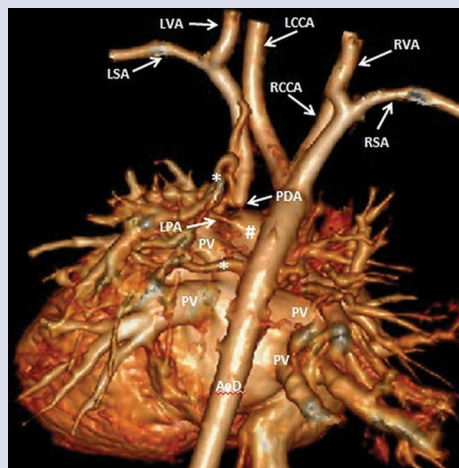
Computed tomography angiography. Three-dimensional virtual reconstruction. Posterior view; LPA — left pulmonary artery; PDA — trivial patent ductus arteriosus; AoD — descending aorta; PV — pulmonary vein; LSA — left subclavian artery; LVA — left vertebral artery; LCCA — left common carotid artery; RCCA — right common carotid artery; RSA — right subclavian artery; RVA — right vertebral artery; #Right pulmonary artery; *aortopulmonary collaterals
